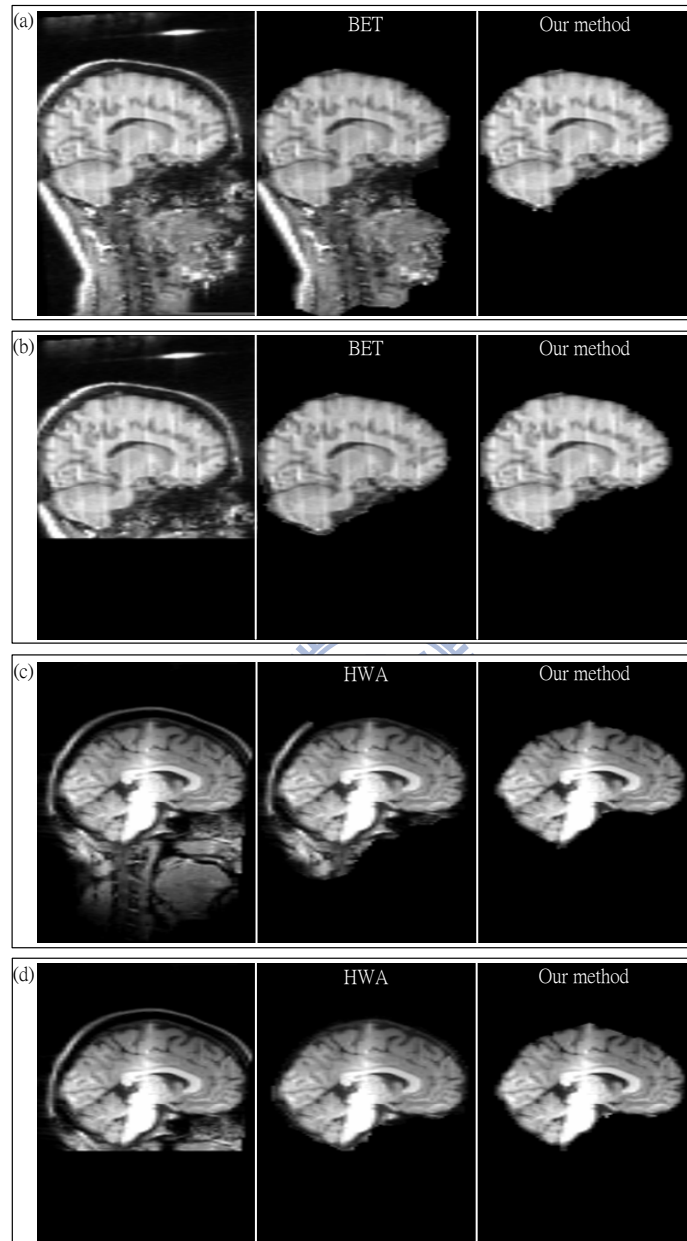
Excess non-brain tissues affect the extraction accuracy of BET and HWA. The MR images of the first IBSR data set contain neck areas, as shown in the left of (a) and (c). In this case BET and HWA cannot well extract the brain volumes, as shown in the middle of (a) and (c). Manually removing several inferior non-brain slices, as shown in the left of (b) and (d), can facilitate BET and HWA to produce better extraction results, as shown in the middle of (b) and (d). On the other hand, the proposed method is relatively robust to the excess non-brain tissues, as shown in the right from (a) to (d).
